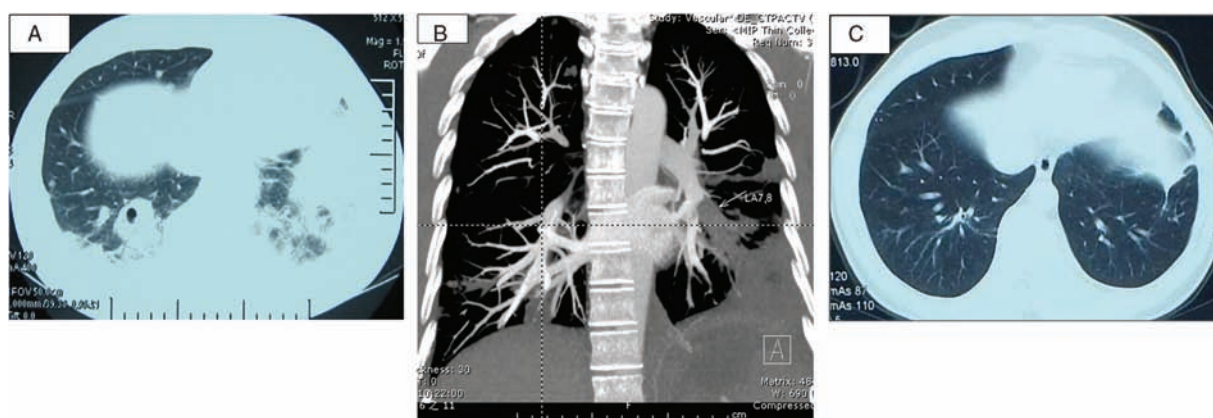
A 44-year-old non-drug user and healthy man suffered from SPE after his right big toe was accidentally injured by a falling iron bar. The chest CT showed multiple nodules, cavities, and patches in both lungs (A). His CTPA showed multiple pulmonary embolisms (B). The repeated chest CT, which was performed after cardiac surgery (tricuspid vegetation removal and valvuloplasty), and antibiotics showed his lung shadows had disappeared (C). CT=computed tomography, CTPA=CT pulmonary angiography, SPE=septic pulmonary embolism.
